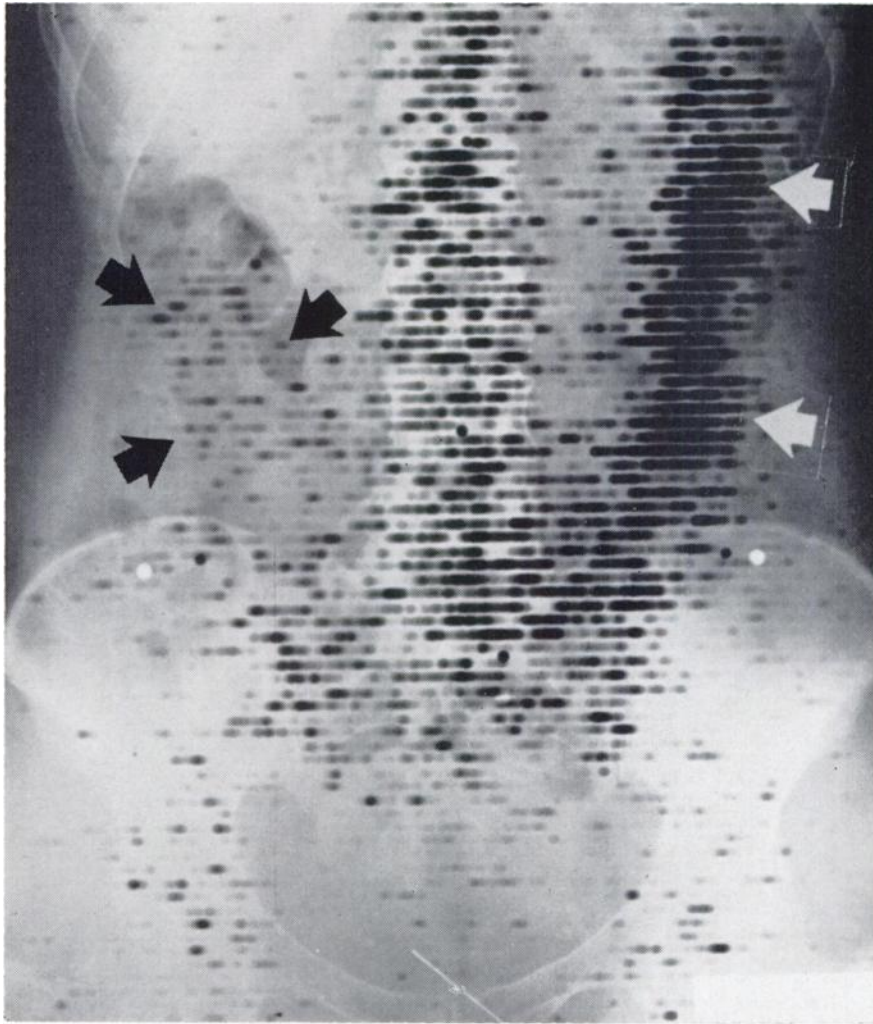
This 36 year old female had an abdomino-perineal resection and colostomy 11 months previously for adenocarcinoma of the rectum, and recently developed back pain. X-rays were negative. Note Sr⁸⁵ deposition in vertebral column, sacrum, sacroiliac joints, acetabula, femoral heads, and colon (arrows). This pattern of distribution is normal. Scanned 4 days following 50 μ c of Sr⁸⁵
